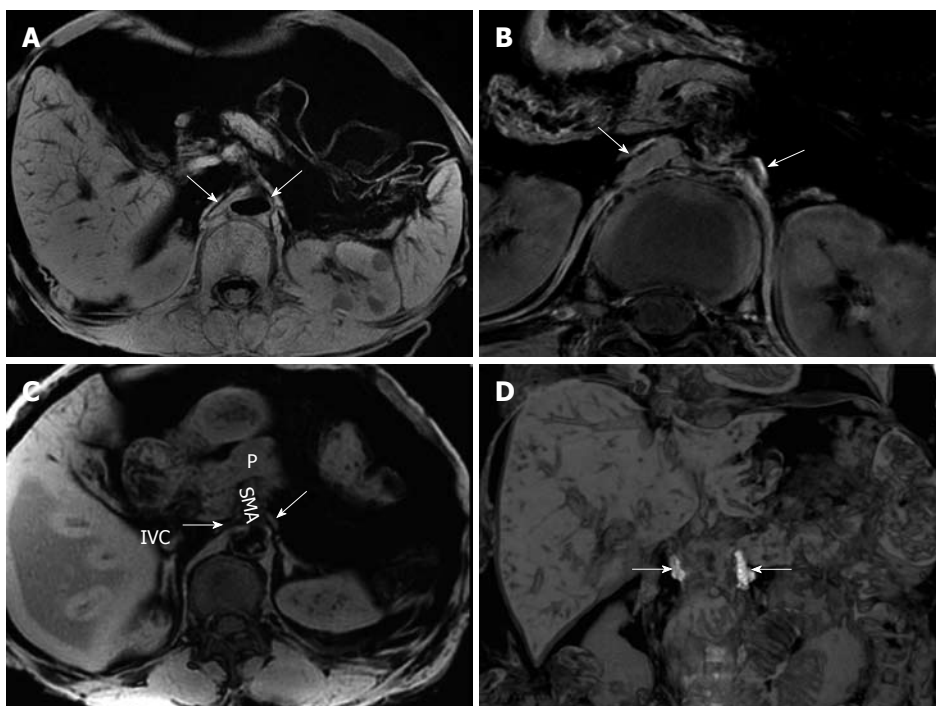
The celiac ganglia on an magnetic resonance imaging. A: A gradient-refocused-echo T1-weighted image shows that both the right and left celiac ganglia (arrows), labeled with Gd-DTPA, have a higher signal intensity than that of the viscus, such as the liver and spleen; B: 3D T1-weighted image shows that both the right and left celiac ganglia labeled with Gd-DTPA (arrows) have a higher signal intensity than the kidneys; C: A gradient-refocused-echo, T1-weighted, out-of-phase image shows the right and left celiac ganglia (labeled with arrows). The right celiac ganglion was located in the space formed by the inferior vena cava (IVC), right adrenal gland, right diaphragmatic crura, head of pancreas, and superior mesenteric artery (SMA). The left ganglion was located in the open space formed by the left adrenal gland, left diaphragmatic crura, and SMA. The celiac ganglia are labeled with gadolinium; D: Coronal imaging on T1-weighted images shows the celiac ganglia labeled with Gd-DTPA (arrows). P: Pancreas.
